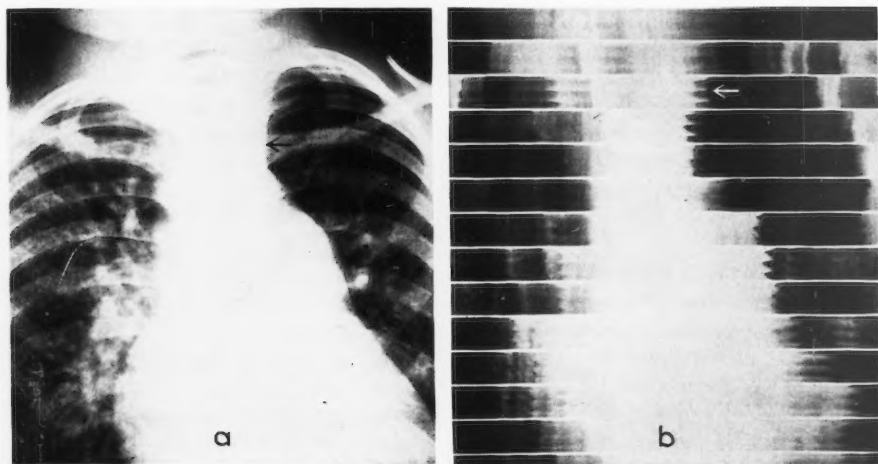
Coarctation of the aorta; patent ductus arteriosus. The patient was a boy 7 years of age. There was a widened brachiocephalic vessel shadow (left common carotid) pulsating as shown in kymogram (b); the pulsations were obvious fluoroscopically. Clinically there was absence of the left radial pulse and signs of patent ductus and coarctation. Roentgenologically the heart appeared large; the trunk and branches of the pulmonary artery were very large; the aortic arch was small. There was no rib notching. On surgical exploration, coarctation was found beginning proximal to the origin of the left subclavian artery; the left common carotid was greatly enlarged; there was a large patent ductus arising proximal to the coarctation.
